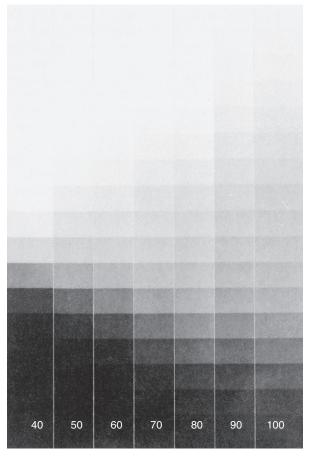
Radiographs of an aluminum step wedge (penetrometer) demonstrating change in contrast with varying voltage. (Courtesy Carestream Health.)
